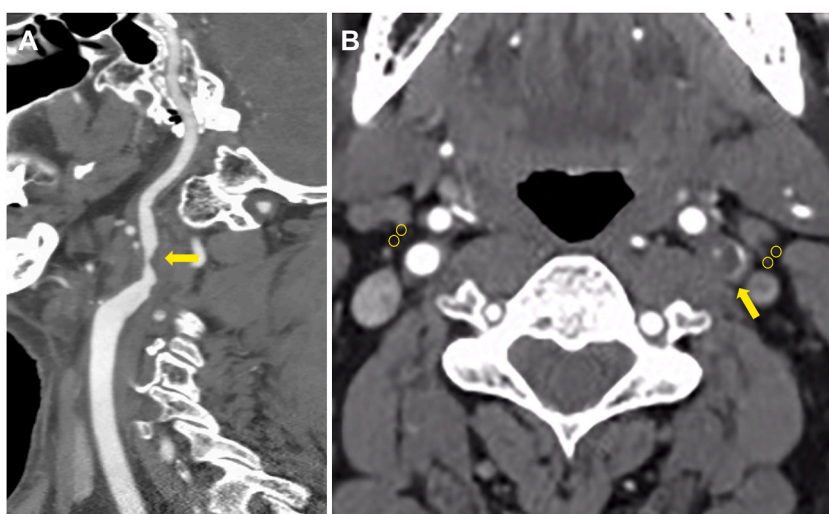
Preoperative carotid CTA image to measure PFD. A: Sagittal view showing the site of maximal stenosis of the proximal internal carotid artery (yellow arrow). B: Axial view showing two ROIs (yellow circles), placed in the perivascular fat for measured PFD. In this case, the two left ROIs were –42.8HU and –43.2HU, and the two right ROIs were –72.8HU and –63.8HU. (For interpretation of the references to colour in this figure legend, the reader is referred to the Web version of this article.)
